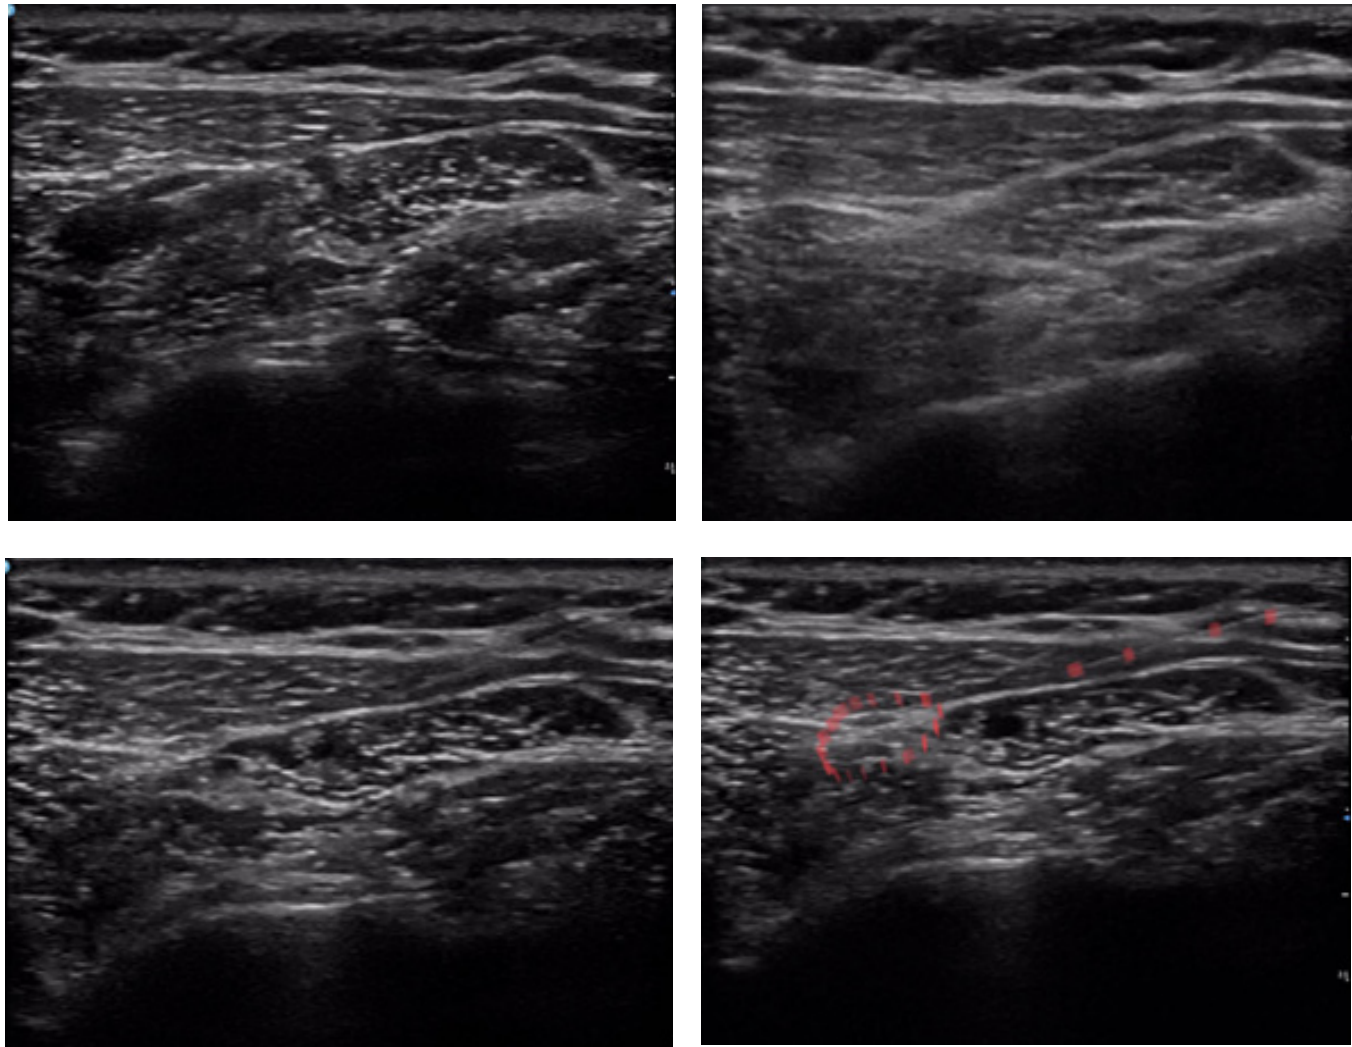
Ultrasound-guided nerve block.
